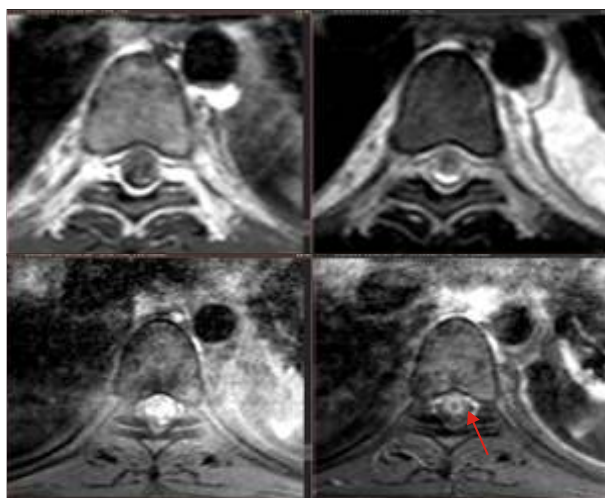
Axial images of MRI spine reveal, peripherally enhancing intramedullary lesion with bilateral pleural thickening and left sided pleural effusion. No significant peri-vertebral soft tissue component is noted.
